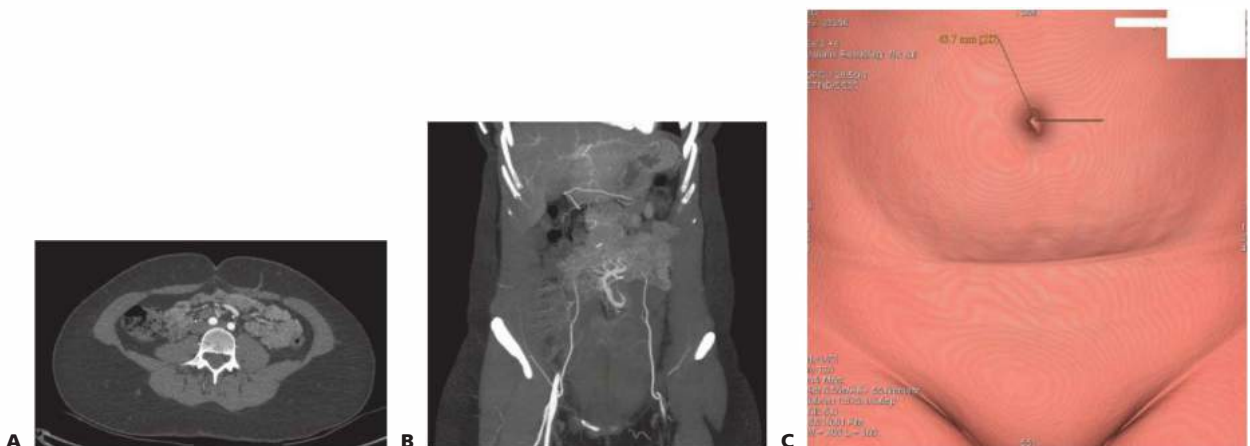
• A,B. Preoperative CT angiography of the lower abdomen. C. A 3-D rendering of the abdominal soft tissue. Perforator locations based on axial cuts are transposed to the skin surface to enhance preoperative planning.
